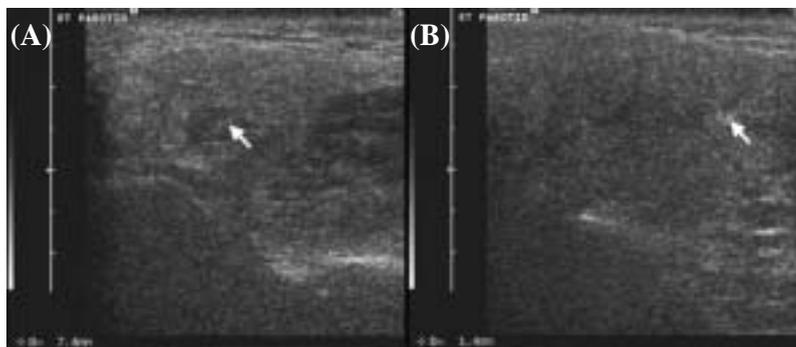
Sonography of the right parotid gland. (A) Dilatation of the proximal parotid duct (arrow); 7.8 mm in diameter. (B) Dilatation of the distal parotid duct (arrow); 1.4 mm in diameter.
